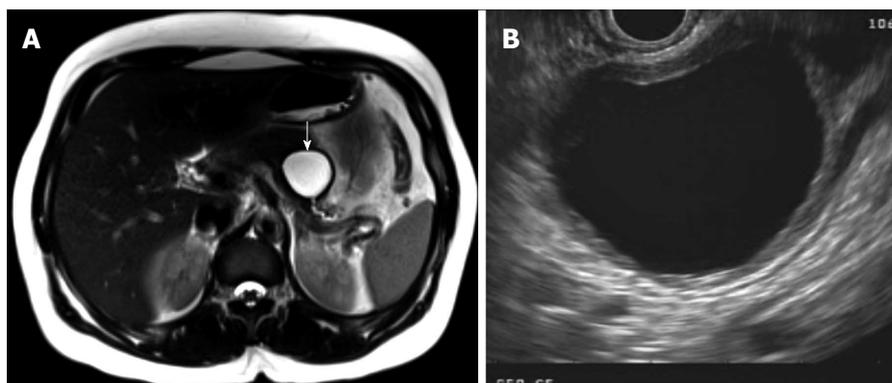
Mucinous cystic neoplasm seen on magnetic resonance imaging (A, arrow pointing to mucinous cystic neoplasm) and endoscopic ultrasound (B), with unilocular appearance and thick wall.
